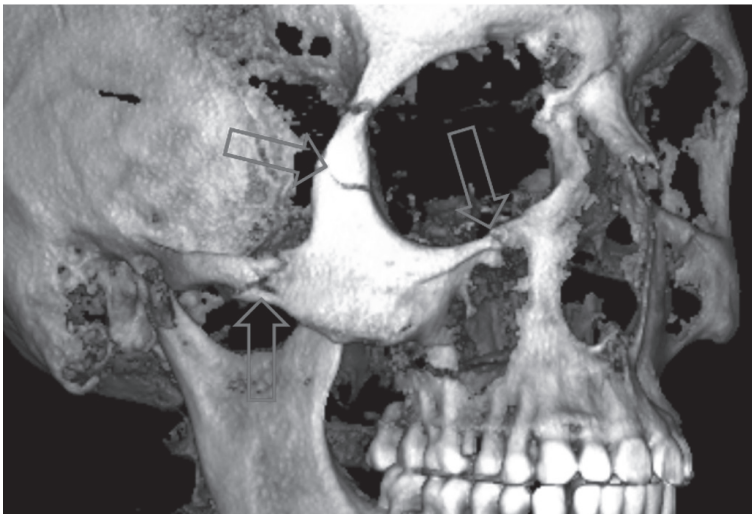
Maxillofacial fractures on 3D reconstruction image of CBCT. Fractures on the right zygomatic arch and orbital fractures.
